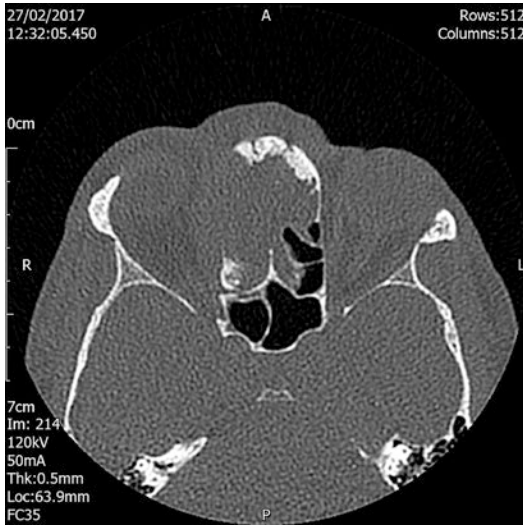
Axial CT scan of the paranasal sinuses demonstrating a destructive lesion involving both ethmoid and frontal sinuses and the right orbit
